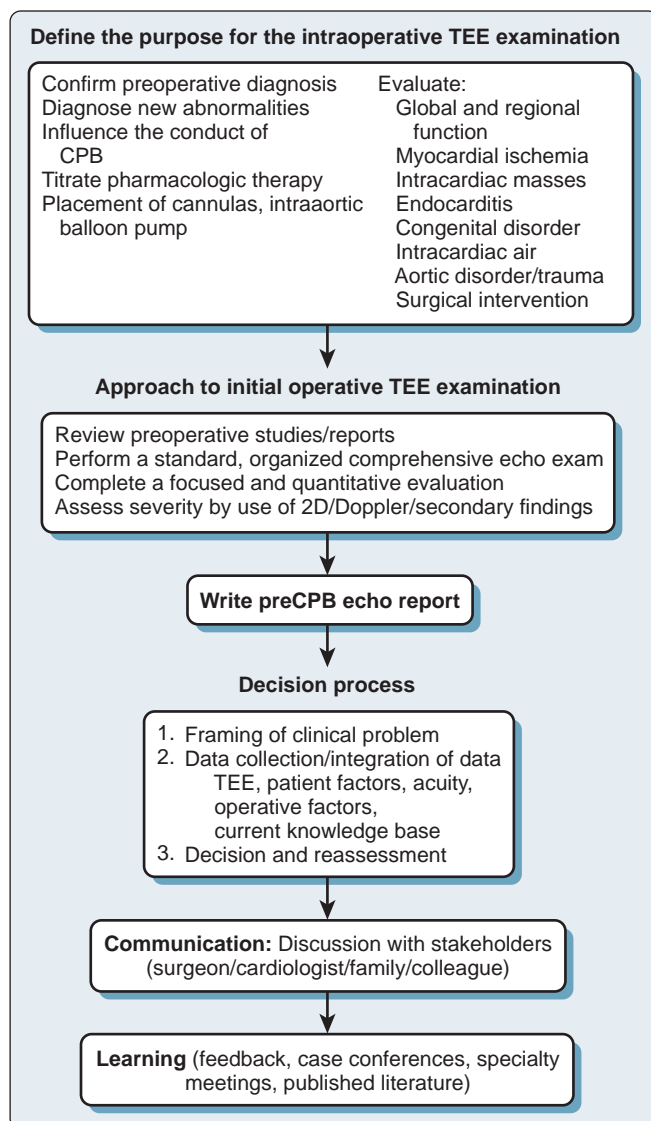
An algorithm for the decision-making process. CPB, Cardiopulmonary bypass; TEE, transesophageal echocardiography; 2D, two-dimensional.
